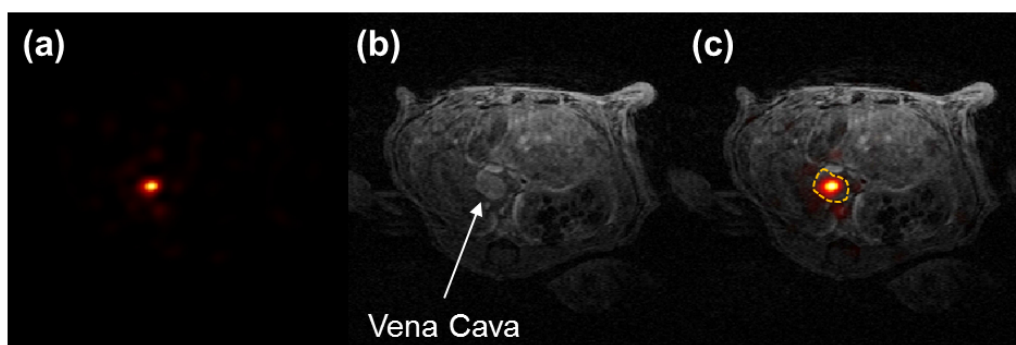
Identification of the vena cava on (a) ^{18}F -FDG MAP early frame image (15s after injection start, frame duration of 5s) and (b) Whole body FISP MR images. A fusion of the PET and MR images is shown in (c).
